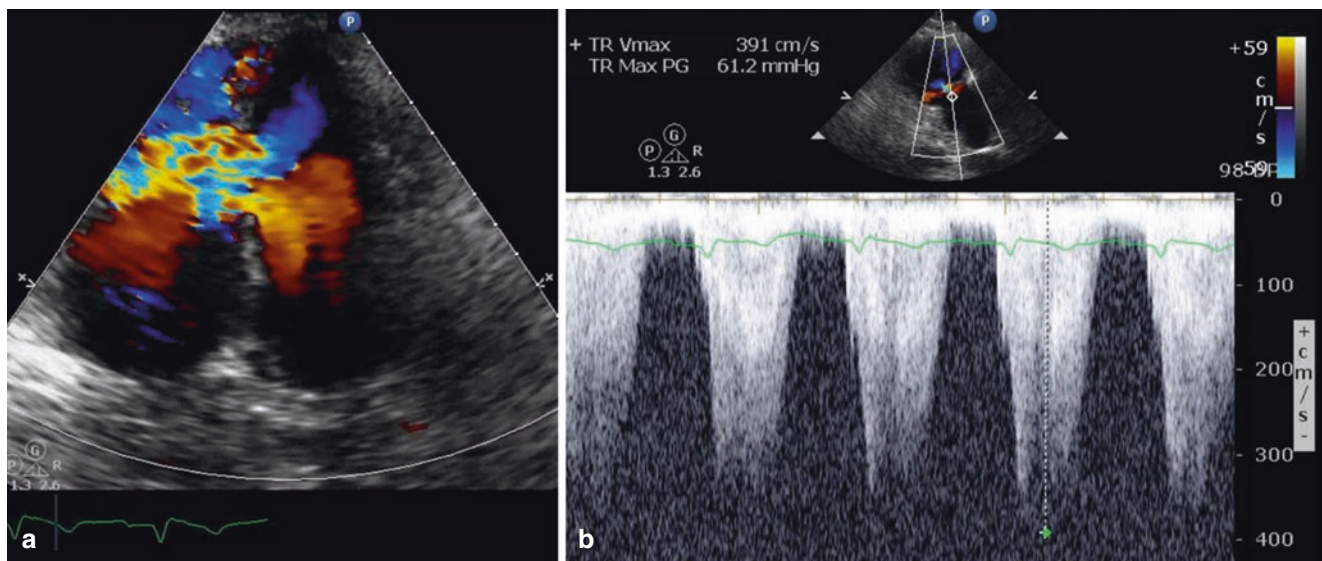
Case presentation. We present a case of a large muscular VSD to demonstrate the benefits of integrated imaging. (a) The color Doppler on the transthoracic echo (TTE) shows a large muscular VSD
